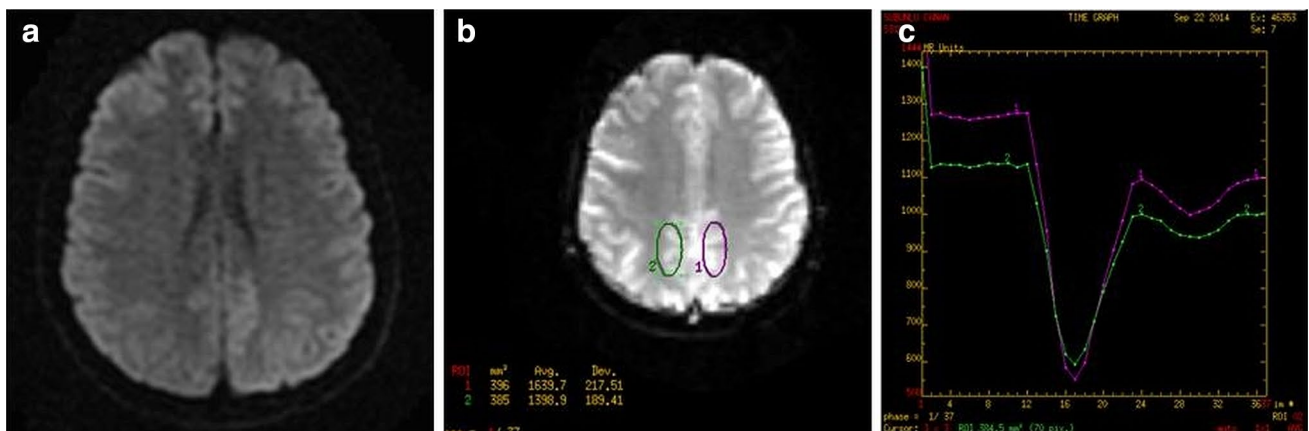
Diffusion and DSC perfusion MR images of a 27-year-old female patient with headache. a No diffusion restriction on diffusion weighted imaging. b A minimal rCBC increase was observed
